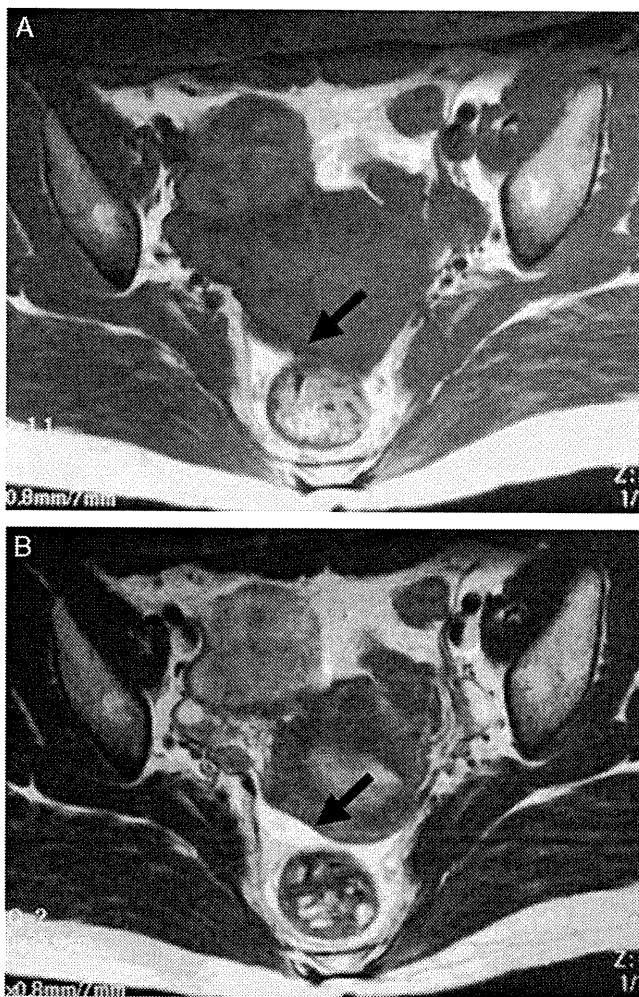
T1 (A) and T2 (B)-weighted axial magnetic resonance images of the pelvic region showing fluid in Douglas pouch (arrows).
